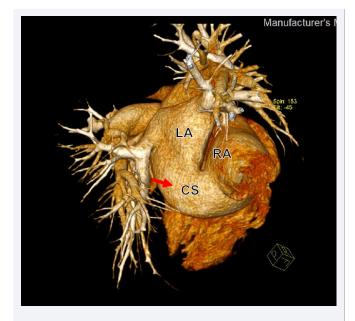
Cardiac computed tomography angiography (CCTA) threedimensional reconstruction showing the unroofed dilated CS.
